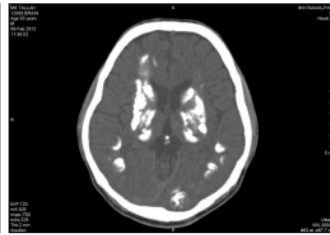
Axial CT slice showing calcification of basal ganglia and subcortical white matter.
